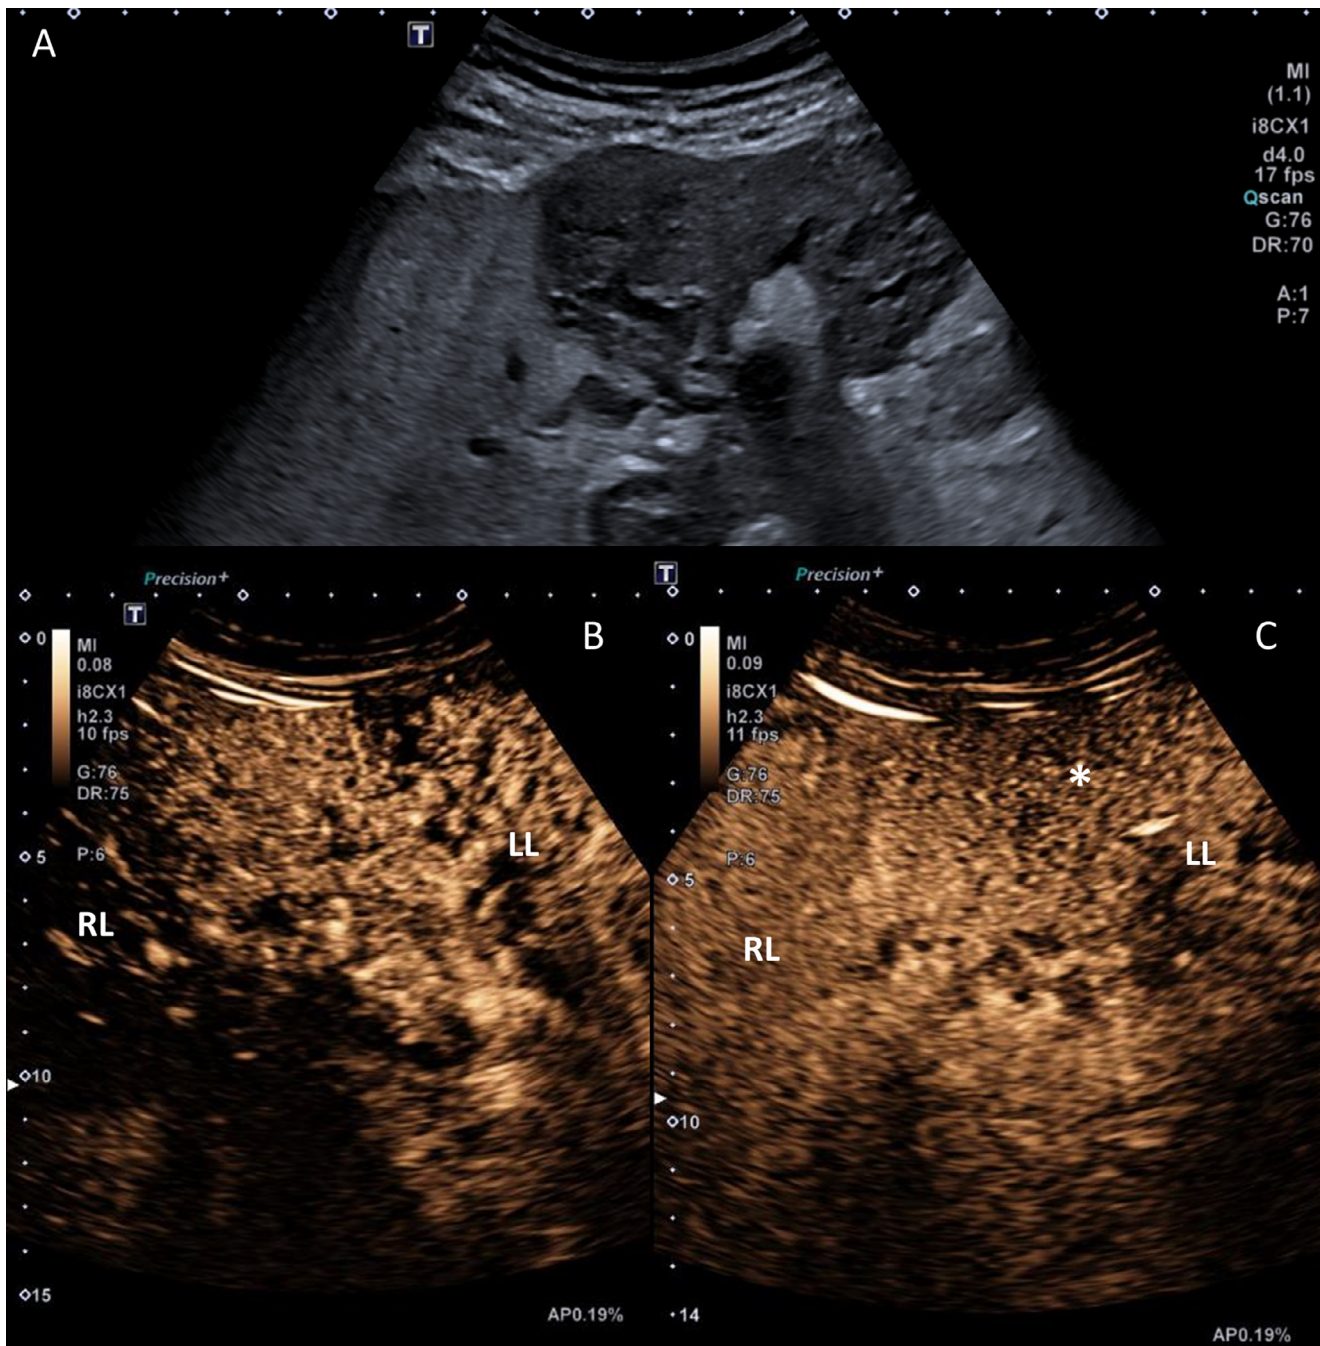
Ultrasound with B-mode indicating a diffusely altered echogenicity of the left liver lobe (A). Contrast-enhanced ultrasound (CEUS) images acquired in arterial phase (after 33 seconds, B) and late venous phase (after 3 min, C) show early arterial inflow in the left liver lobe (LL) compared to the right liver lobe (RL). Washout in the left lobe (asterisk) was only present in superficial area, while the dynamic examinations cannot differentiate real lesion washout from bubble destruction in the near field, as the left lobe showed inhomogeneous washout in the late contrast phase.
